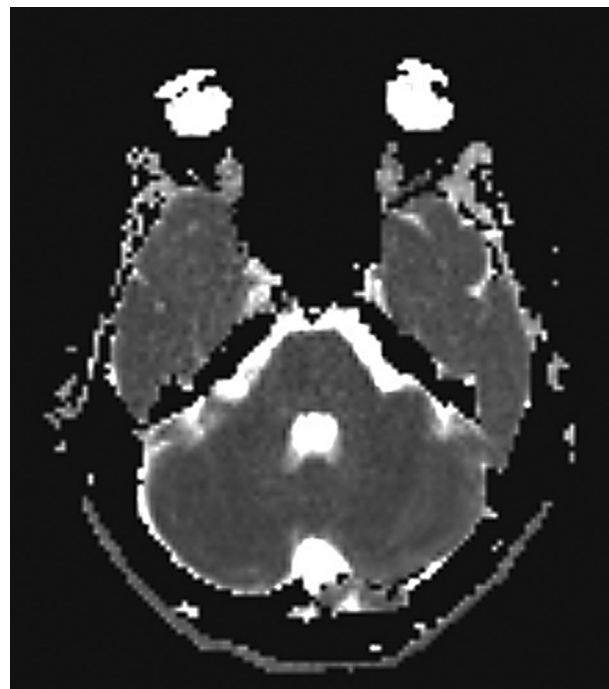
Brain MRI ADC sequence. No evidence of diffusion restriction.
